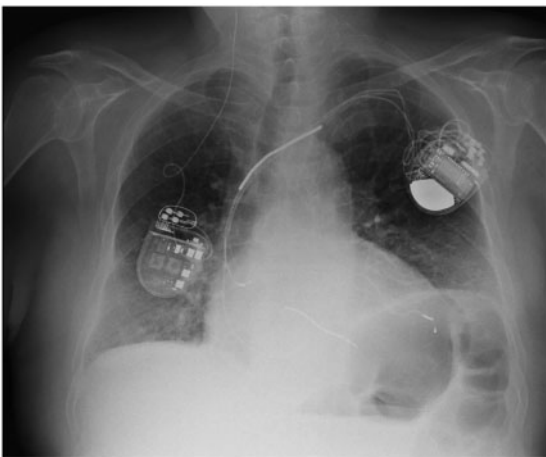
Chest X-ray shows implantable cardioverter-defibrillator-cardiac resynchronization therapy (left) and the Barostim Neo® device (right).
